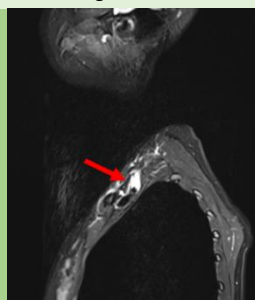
Sagittal T2-weighted MRI of the brachial plexus
